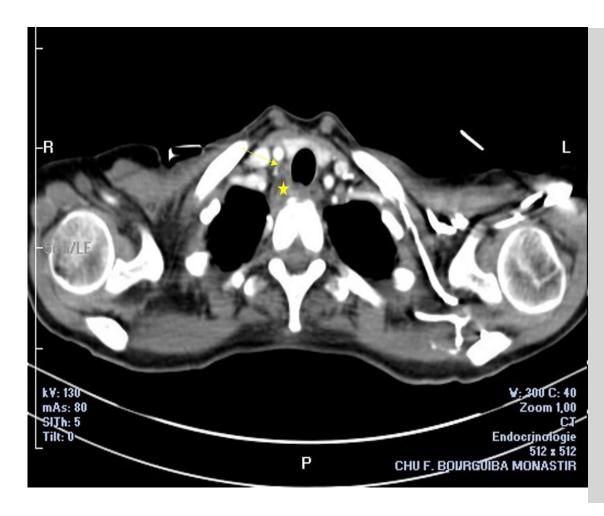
Axial cervical CT-scan showing the retropharyhgeal hematoma (star) with a right retrothyroid gland nodule that correspond to a parathyroid gland (arrow)
